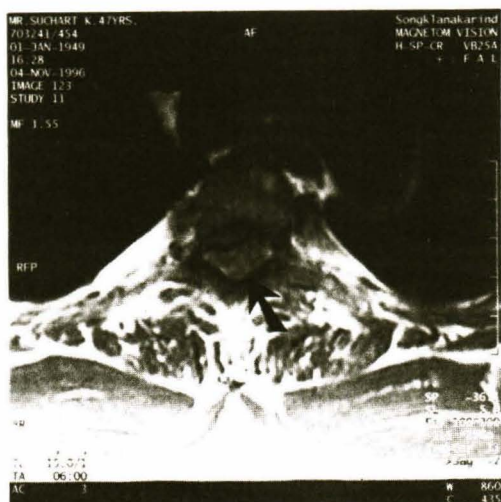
MRI, axial T1 weight image show the mass (arrow) displaced thecal sac anteriorly.
